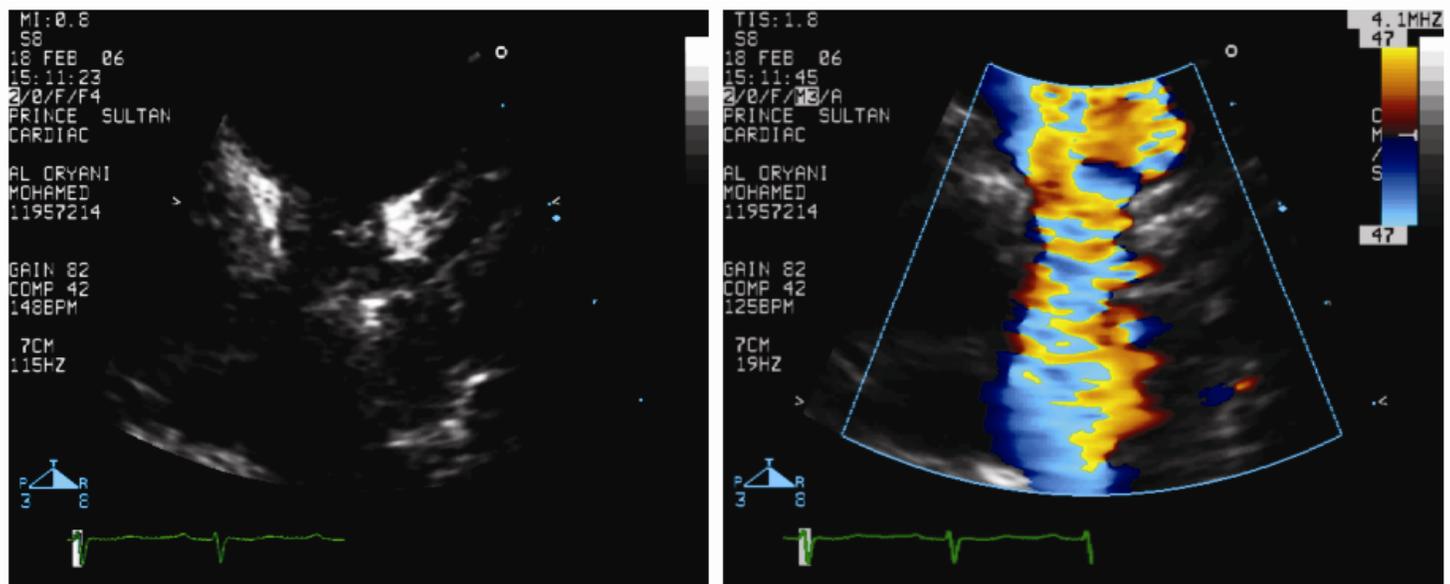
2-D and color-Doppler showing pulmonic valve stenosis with LCA arising from the pulmonary artery.
